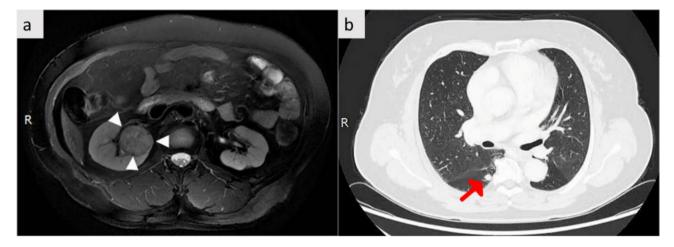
Abdominal magnetic resonance imaging (MRI) revealed a right renal tumor measuring 35 × 33 × 32 mm (the white head of arrow) (a). Enhanced computed tomography (CT) showed an 8 mm diameter nodule in the right pulmonary (the red head of arrow) (b)
